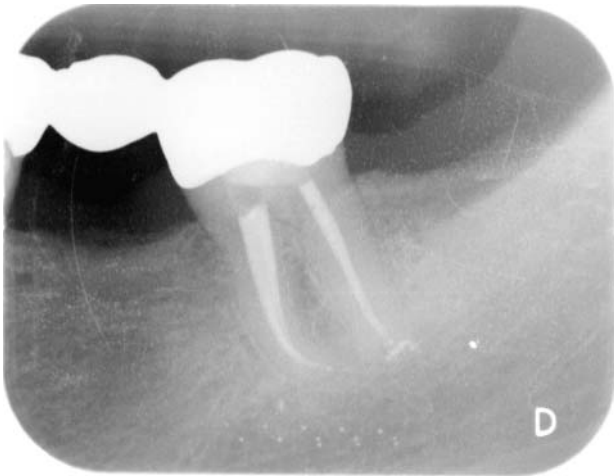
Radiographic 12-month recall.
